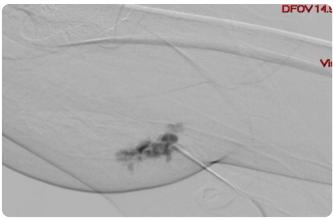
a) Mixed lymphatic malformation located in the right buttock. Linear ultrasound identifies an image with multiple cysts of variable size, with fine septa and a fibrous component. b) Sclerotherapy with alcohol of the lesion located in the buttock under fluoroscopic vision. c) Noticeable improvement of the lesion, with disappearance of the cystic lesions.
